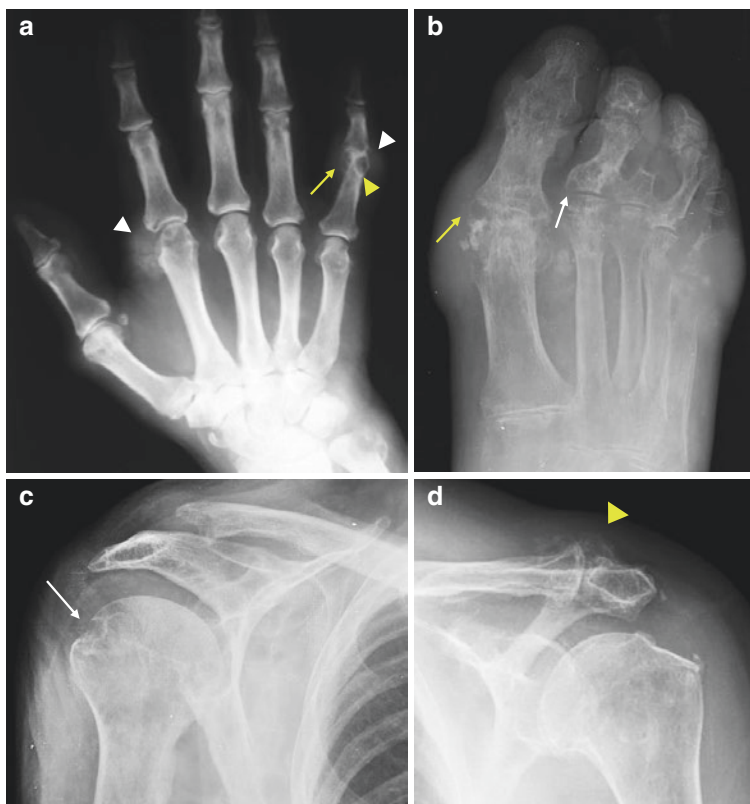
Radiographic findings in gout
